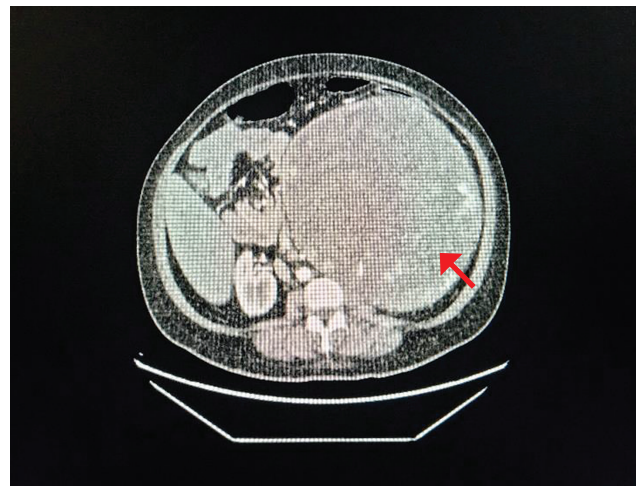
CT scan of the abdomen on axial view showing the left adrenal mass (red arrow) occupying the bulk of the left intraabdominal space.
